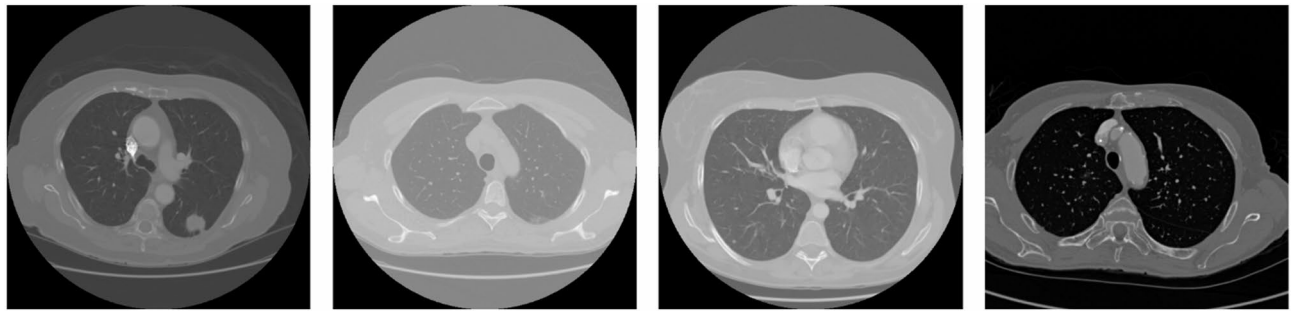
Representative CT scan images from the LUNA16 dataset displaying diverse nodule appearances and structures.
